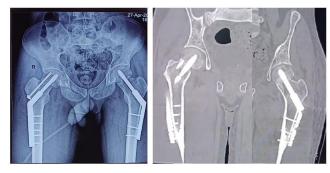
Post-operative anteroposterior radiograph following bilateral DHS fixation
